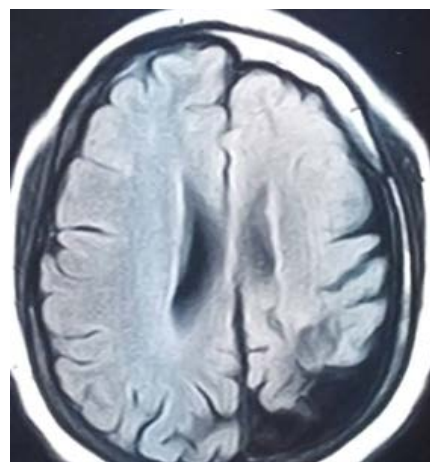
Cerebral MRI sequence T2 FLAIR: Left hemi-cerebral atrophy with cortical calcifications and compensatory hypertrophy of the frontal diploes.
